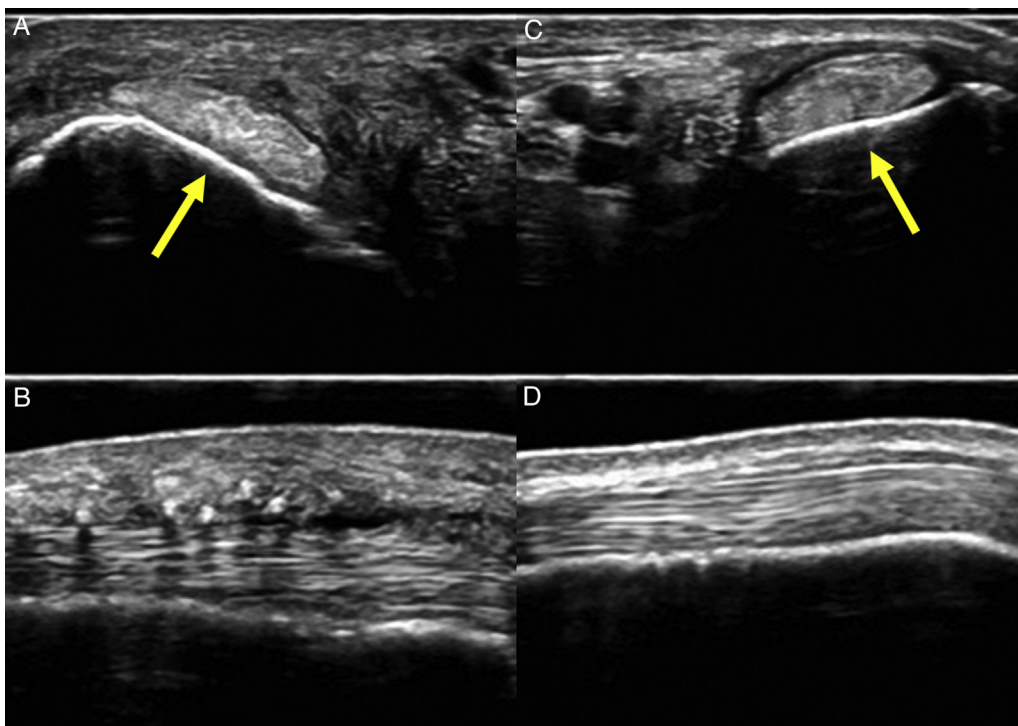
Transverse (A and C) and longitudinal (B and D) ultrasound images of the posterior tibial tendon (PTT) (*arrows*). On the affected side (A and B), the PTT had shifted medially and flattened. The distance between the PTT and flexor digitorum longus tendon was longer than that on the contralateral side. The flexor retinaculum was thickened, and some stitches used in the previous surgery can be seen as hyperechoic dots. An irregularity of the groove surface and a slight loss of the normal fibrillary pattern can be seen. On the contralateral side (C and D), the PTT was located in the retromalleolar groove. The flexor retinaculum showed normal thickness and inserted onto the medial edge of the groove.
